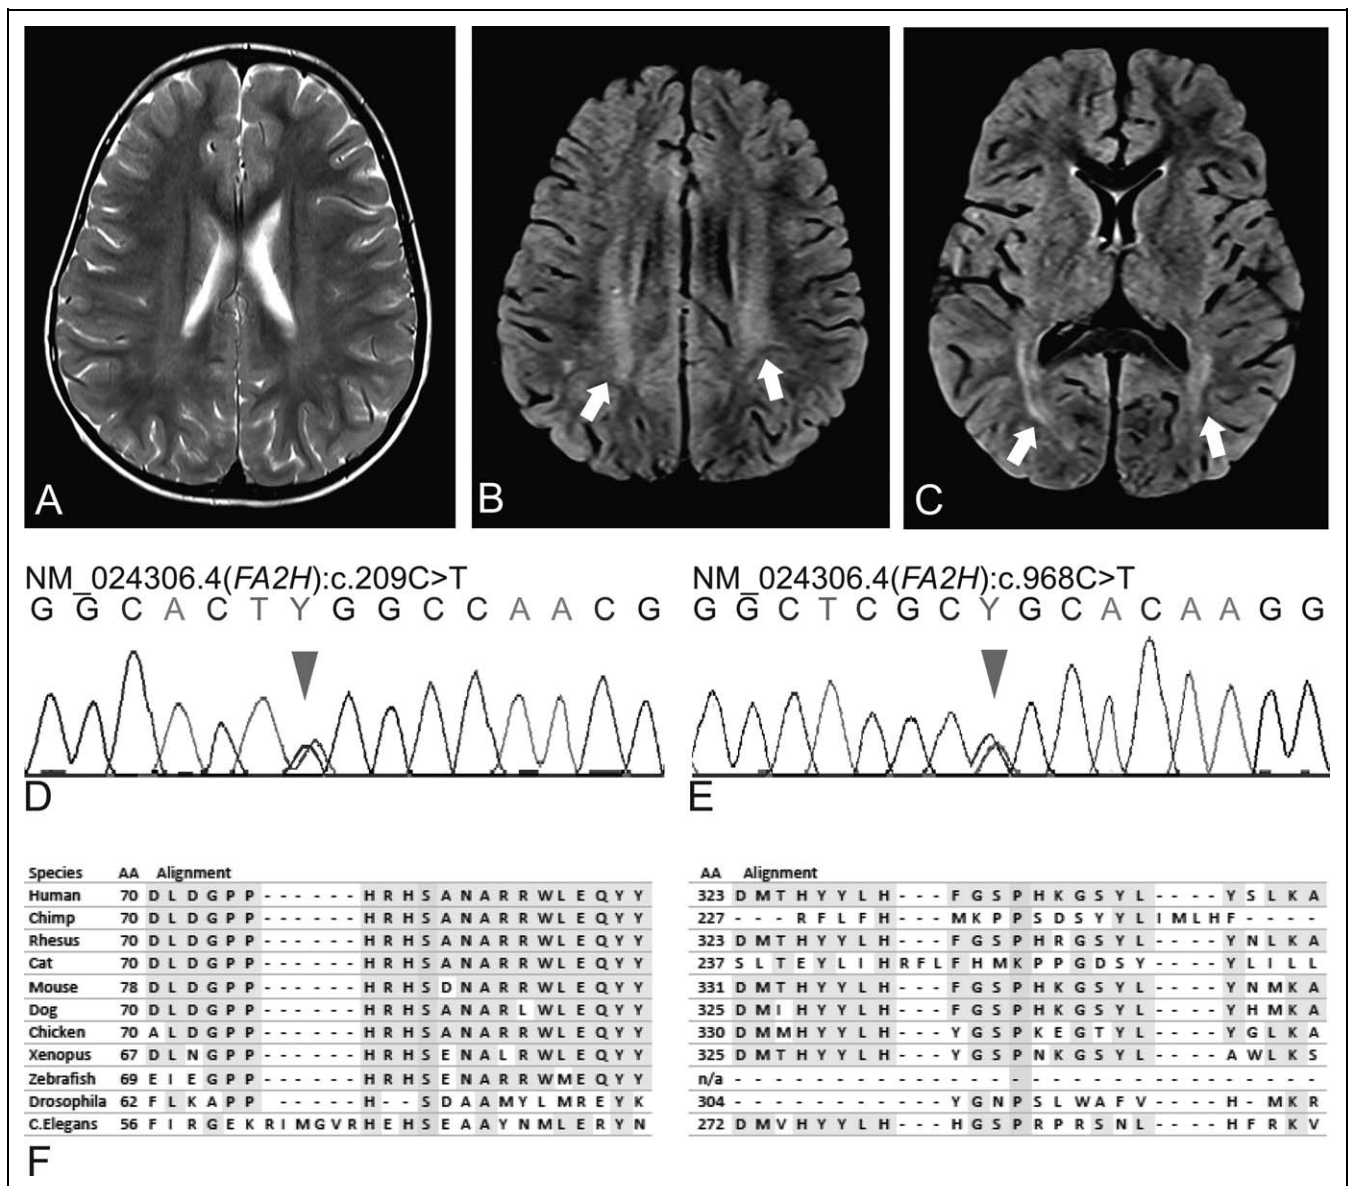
Diagnostic studies in the proband with progressive spastic paraparesis. The brain magnetic resonance imaging showed normal grey/white matter differentiation, and abnormal high-signal-intensity areas in the periventricular white matter with a posterior predominance (white arrows) seen on both axial T2 (A) and axial fluid-attenuated inversion recovery (B, C) sequences. Panels D and E show the partial chromatograms of Sanger sequencing for exons 1 (D) and 6 (E) of the *FA2H* gene, identifying 2 substitutions confirmed to be in trans by parental segregation (data not shown): c.209C>T in exon 1 (maternal), and c.968C>T in exon 6 (paternal), leading to the substitution of highly conserved amino acids as shown by the orthologous sequences (F): p.S70L (left) and p.P323L (right), respectively. AA indicates amino acid position.
